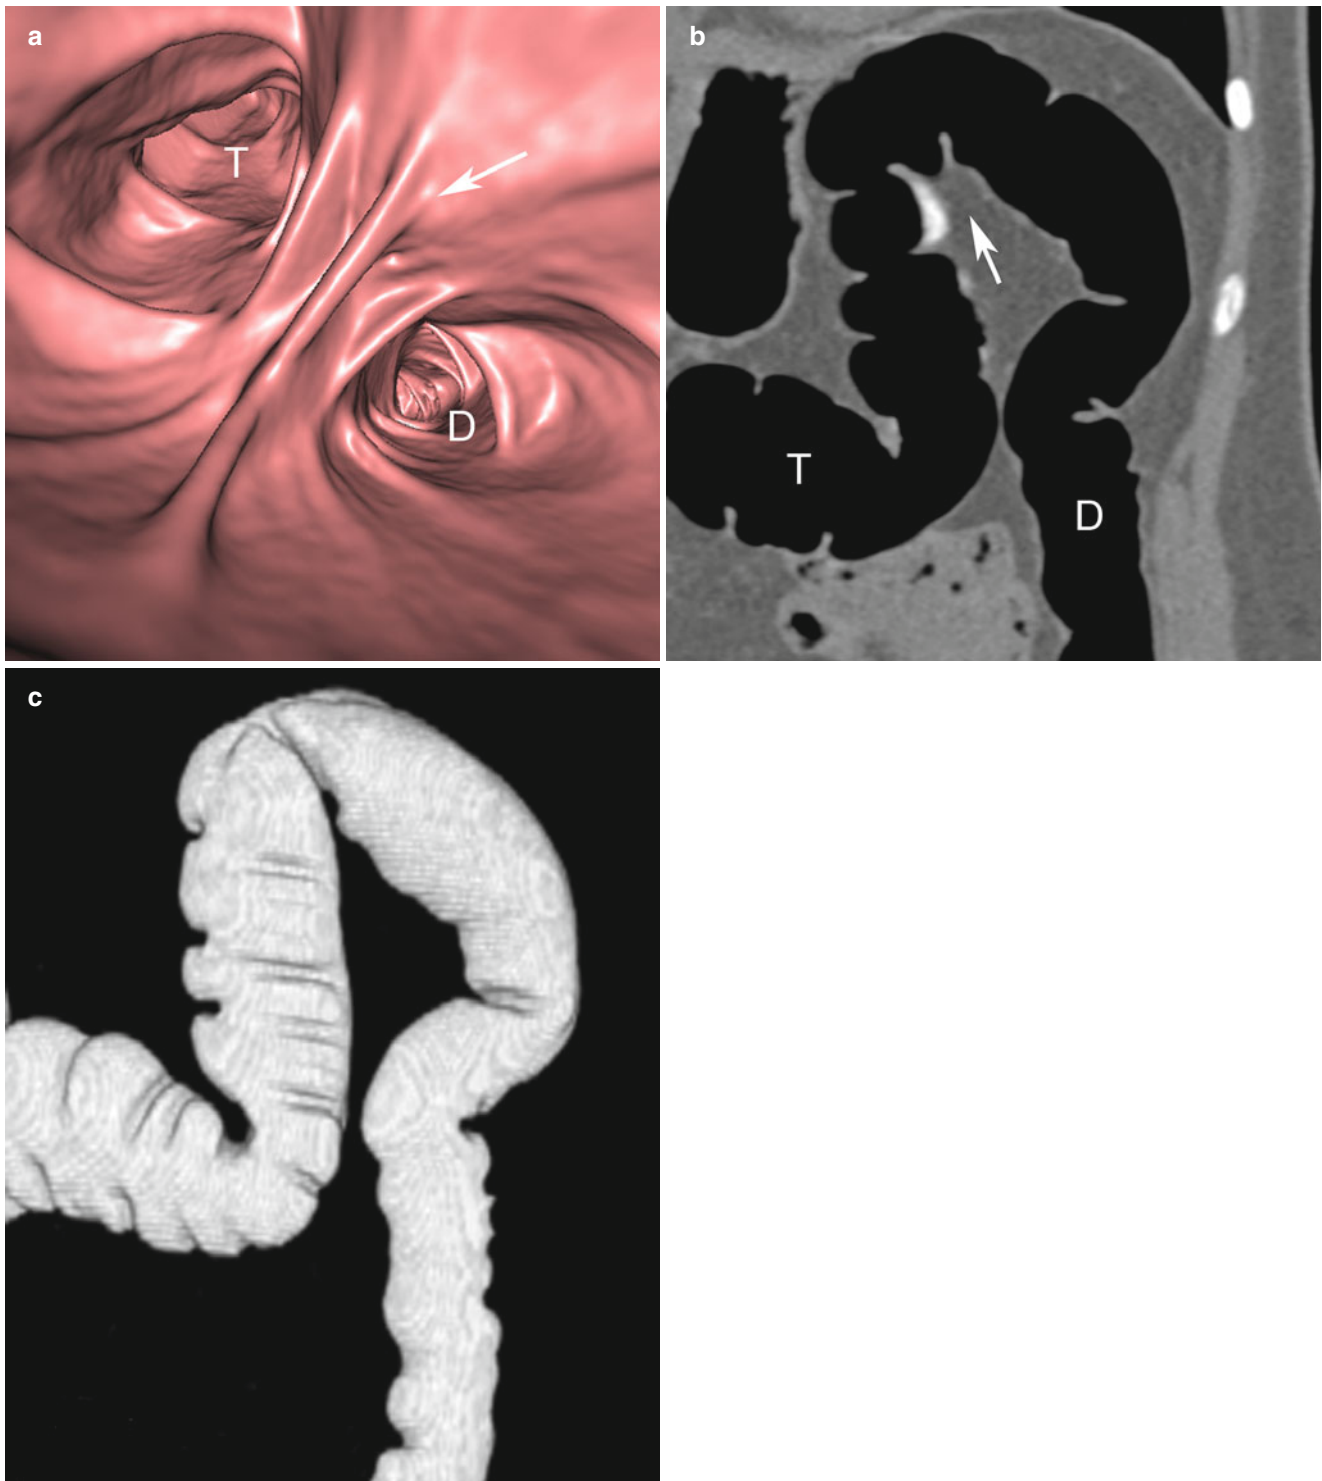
(a) Endoluminal 3D CT view and (b) sagittal 2D image showing the left flexure (*arrow*) connecting the transverse (*T*) with the descending (*D*) colon. (c) Global surface-rendered 3D view shows the course of the left flexure
